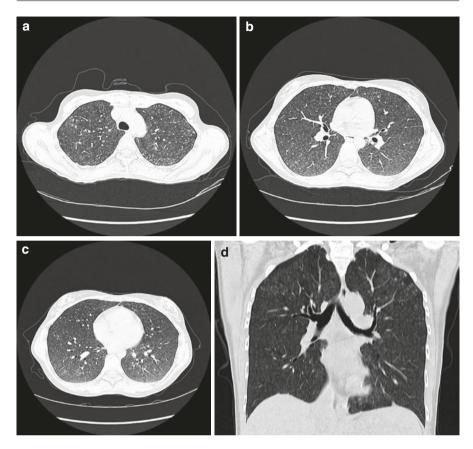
(a) HRCT of the lungs: acute HP with multiple centrilobular nodules. (b) HRCT of the lungs: acute HP with centrilobular nodules, bare fissures. (c) HRCT of the lungs: acute HP with centrilobular nodules, small GGO areas. (d) HRCT of the lungs (coronal reconstruction): acute HP with centrilobular nodules in the whole lung
